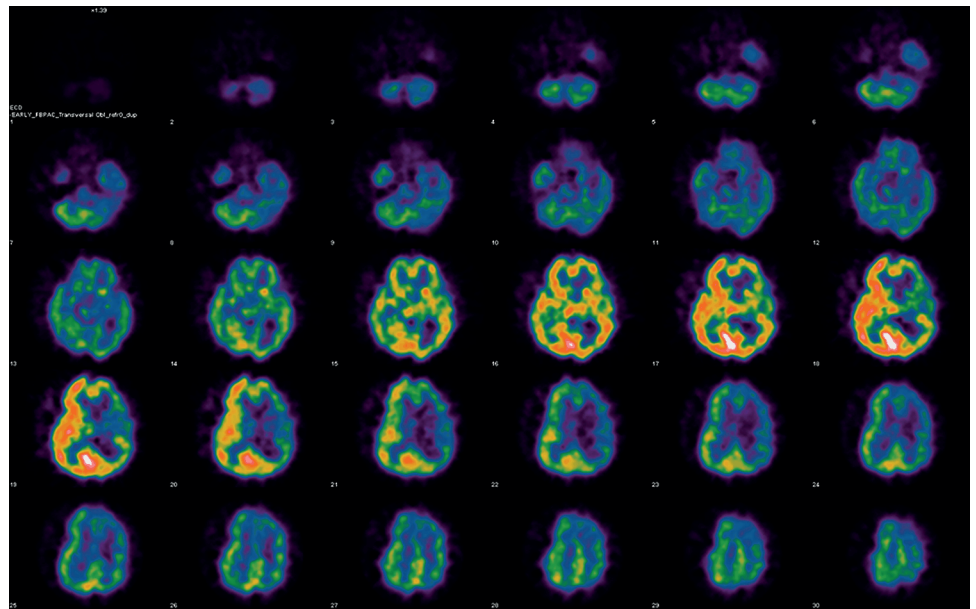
Brain perfusion Tc-99m EDC single-photon emission computed tomography demonstrates hypoperfusion in the left frontal and right temporal regions, and the right basal ganglia.
